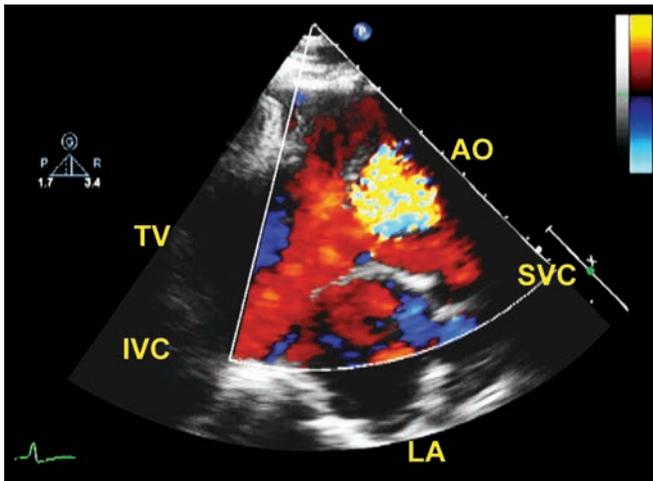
Right parasternal examination. Color Doppler shows flow signals entering RA from both IVC and SVC.
